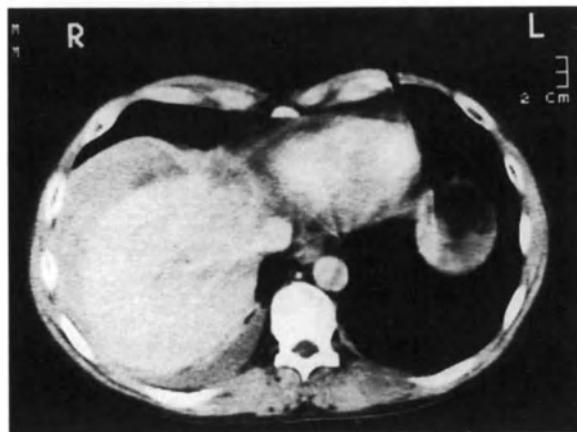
CT scan enhanced. Stab wound. Large subcapsular hematoma.
